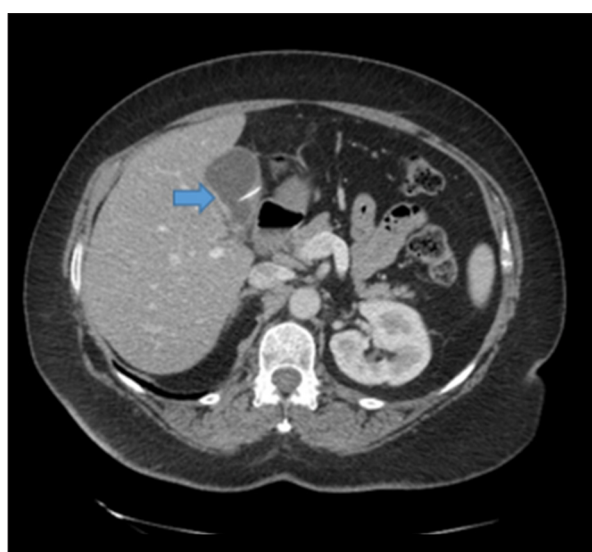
Case 2 – CT scan abdomen and pelvis demonstrating a metallic foreign body entering the gallbladder (blue arrow).
